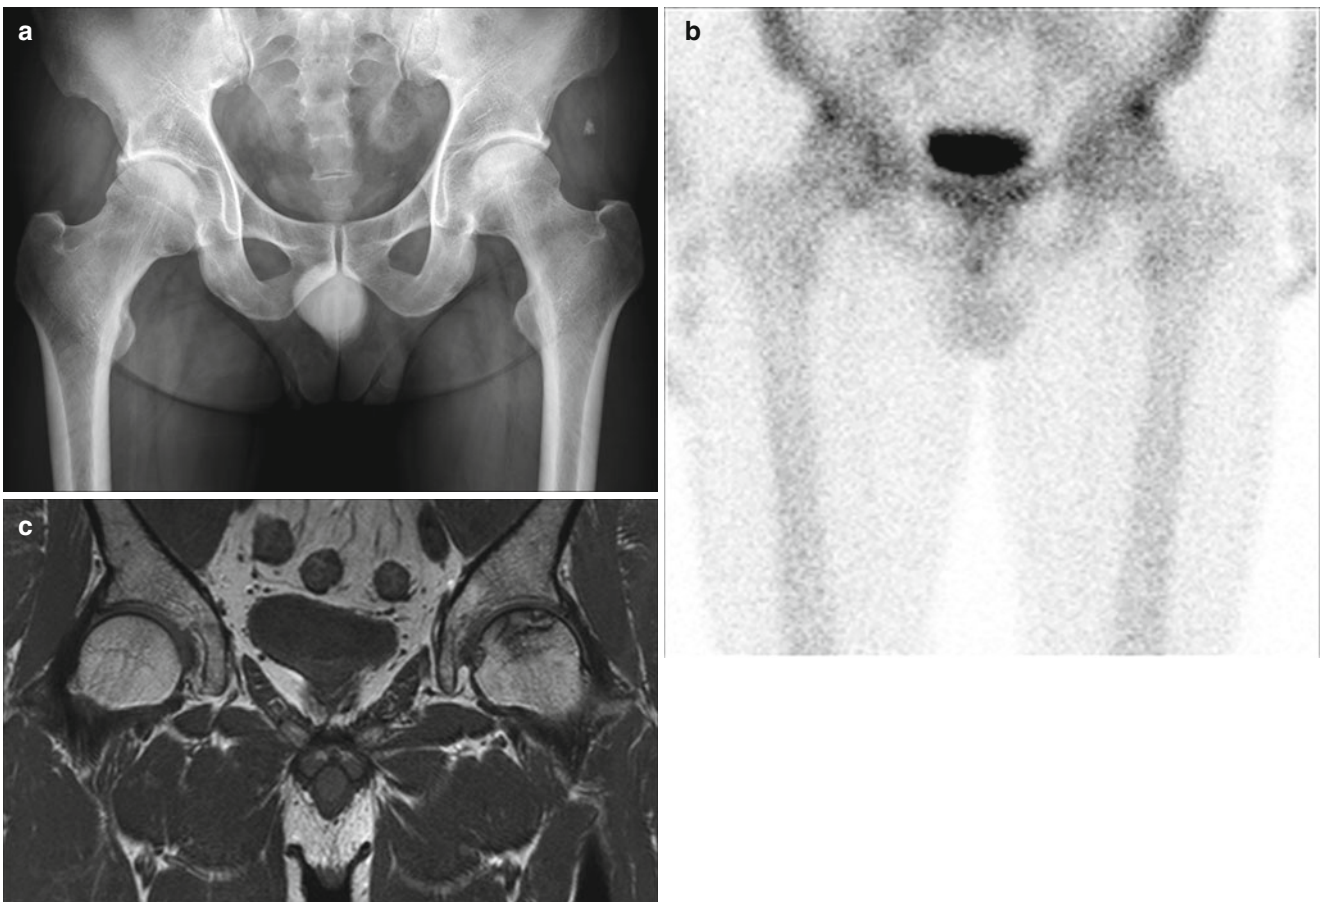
ON of the left femoral head. (a) The hip anteroposterior radiograph was interpreted as normal. (b) Minimally increased uptakes of the radionuclide are noted at the lateral margins of both acetabula on
